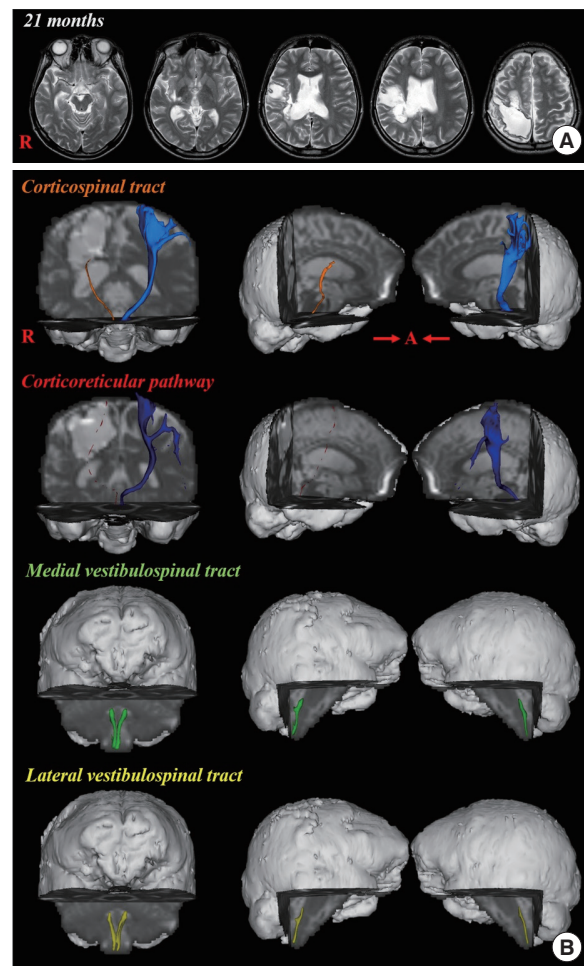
(A) Brain MRI on at 21 months after onset shows injury on the right primary motor cortex, primary somatosensory cortex, corona radiata and basal ganglia due to intracerebral hemorrhage. (B) Diffusion tensor tractography (DTT) of the corticospinal tract (CST), corticoreticular pathway (CRP), medial vestibulospinal tract (VST) and lateral VST in a patient: the CST and CRP in the affected hemisphere showed severe injury aspect compared with the unaffected hemisphere, by contrast, medial and lateral VST in the affected hemisphere showed intact integrity like the unaffected hemisphere. A: anterior, R: right.
